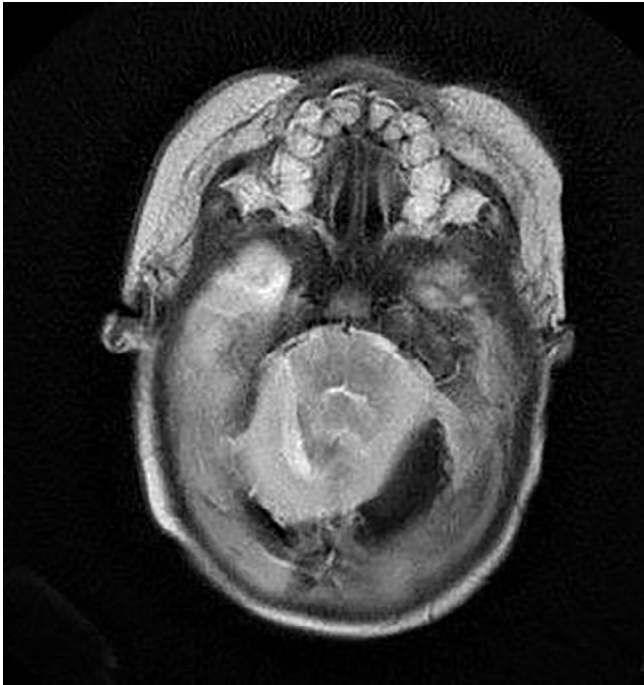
MRI (GRE) showing posterior fossa subdural haemorrhage with blooming effect.
